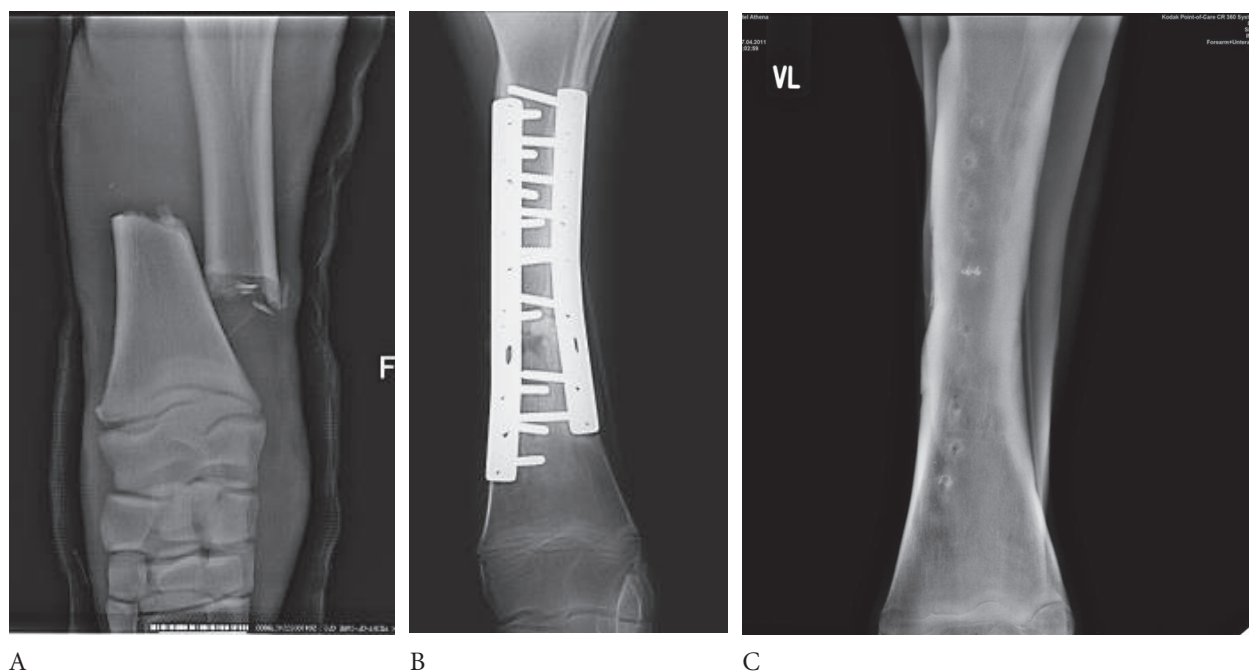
Radiographic evaluation of the left radius. A) Radius fracture at admission to the Clinic. A closed, complete displaced transverse diaphyseal fracture was noted. B) Internal fracture fixation. The region of the cortical bone defect is less radiodense at 9 weeks post surgery. C) Craniocaudal projection of radius, 7 weeks after removal of the cranial plate.
